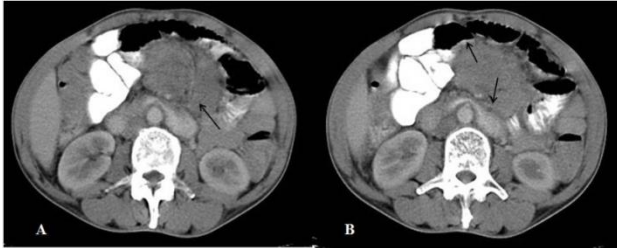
A) Axial CT scan show fatty soft tissue mass (arrow) related to small bowel and mesentery. B) Axial CT scan show peripheral curvilinear band of soft-tissue attenuation (arrow), limiting heterogeneous mass from surrounding normal mesentery known as “tumoral pseudocapsule” sign.
